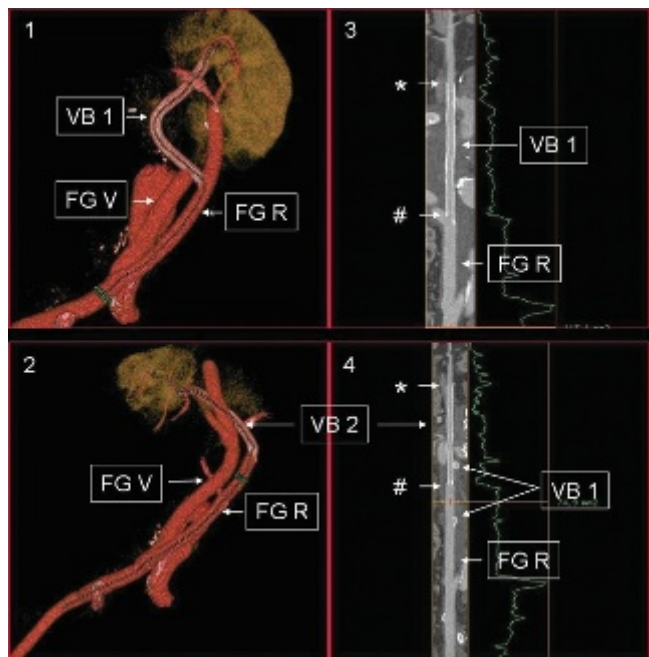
Computed tomographic (CT) scan after 12 months of follow-up. CT reconstruction shows the Viabahn stent graft and the native renal artery. There is no stenosis or myointimal narrowing.
